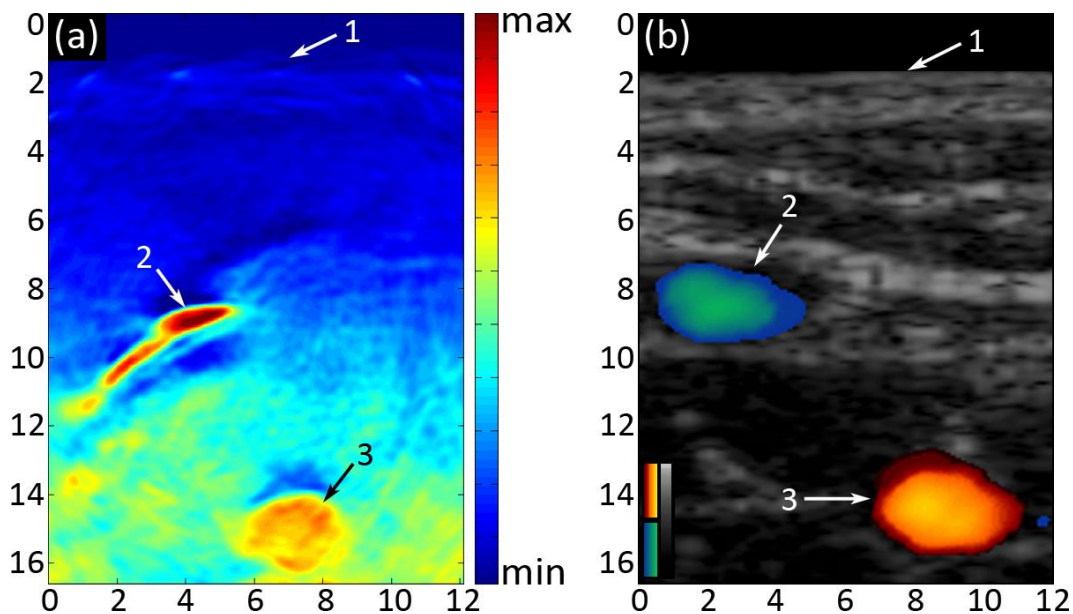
Cross-sections showing lower arm vasculature of a male volunteer 7 cm from the elbow – axes are given in mm. (a) Optoacoustic image using the initial curved array prototype. (b) Directional ultrasonography image, overlaid on standard ultrasonography image in gray, indicating positive flow in yellow/red; negative flow in green/blue. Annotations: 1.Skin surface; 2.Intermediate antebrachial vein; 3.Radial artery.
